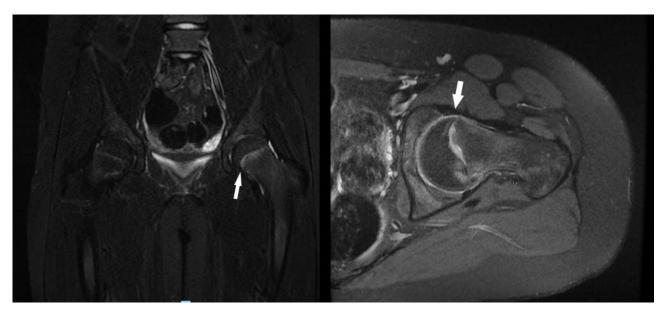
Coronal and axial STIR MRI shows high signal involving the physeal line on the left side with slight widening (arrow). No slippage of the femoral epiphysis. Minimal joint effusion. Mild surrounding bone marrow edema of the epiphysis and metaphysis. Normal right hip joint and proximal femur.
